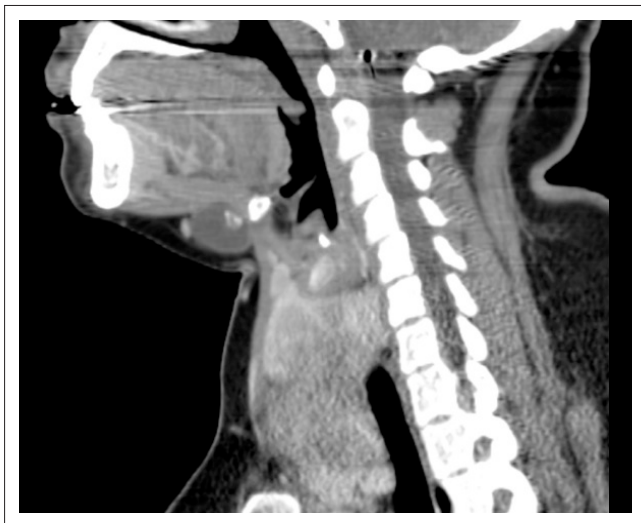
Sagittal paramidline CT scan image.
